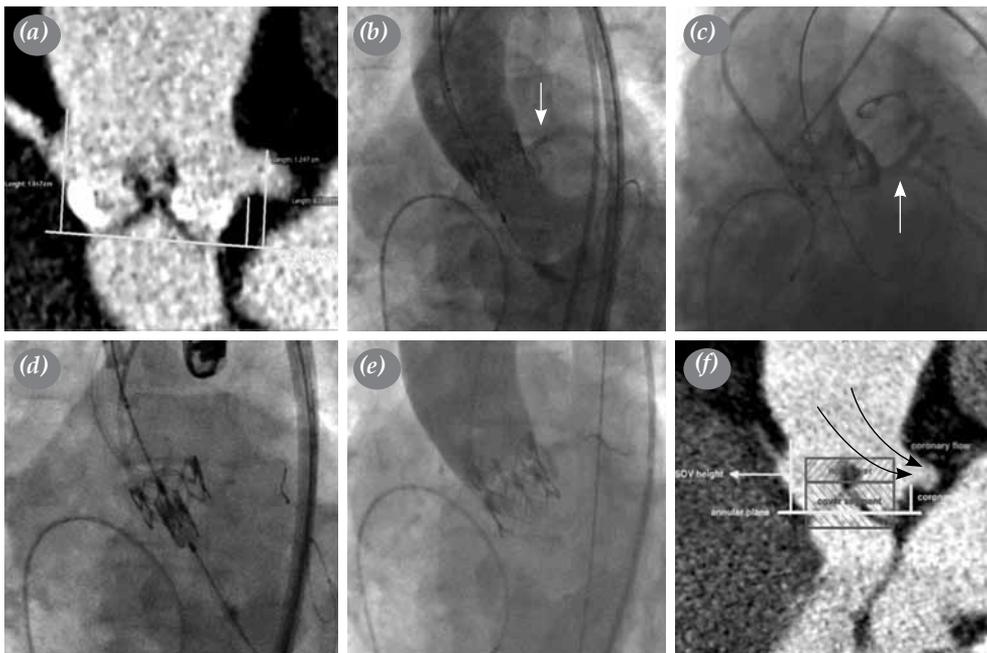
(a) Computed tomography angiographic measurements in the long-axis view for the left coronary artery height and sinus of Valsalva diameter. (b) A malpositioned transcatheter heart valve into the sinus of Valsalva was seen on aortography following the first deployment. (c) Aortography showed no obstruction of the left main coronary artery (white arrow). (d) A second valve as low as possible in the aortic annulus. (e) Good final angiographic results. (f) The possible reason of continuing coronary flow might be the coronary ostia lateral to the stent frame or there might be flow laterally from the open sinuses (black arrow).
